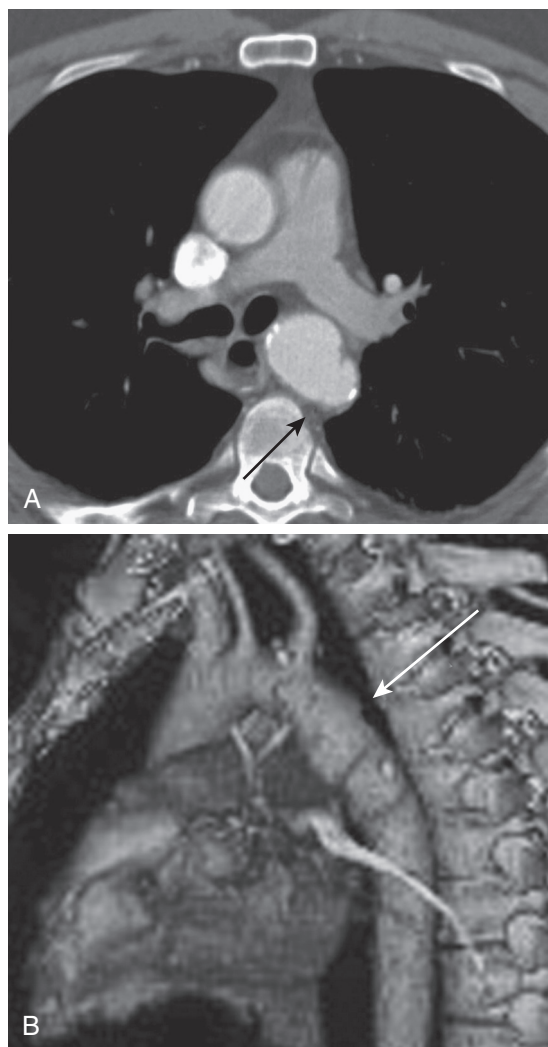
■ Aortic injury with saccular aneurysm (arrows) following chest trauma as seen by CT angiogram (A) and three-dimensional reconstruction (B). (From Steenburg SD, Ravenel JG, Ikonomidis JS, et al: Acute traumatic aortic injury: imaging evaluation and management. *Radiology* 248:748–762, 2008.)
